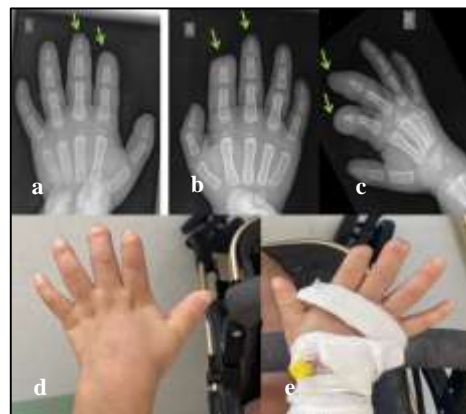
(a-e): Radiographs and clinical photographs showing progressive resorption of bilateral index and middle fingers as a result of self-mutilation resulting in amputations (green arrows).
